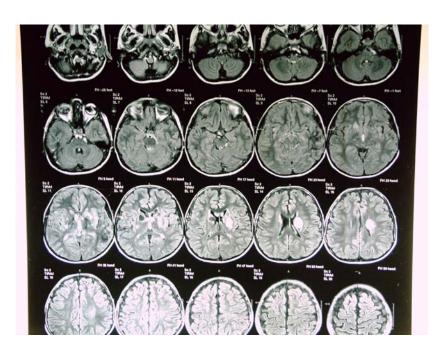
MRI showing a moderate size zone of signal abnormality at the left basal ganglionic/ corona radiata region exhibiting intense bright signal on different weighted images, represents late acute/ early subacute infarcts of left middle cerebral artery territory. This zone shows high signal intensity on FLAIR (Fig. 1b) images. Also, variable zones of signal abnormality with both ganglionic region, mainly the caudate nuclei and left putamenal regions. These exhibit signal intensity which follows CSF on all sequences and as such represent encephalomalacic zones of old infarcts
